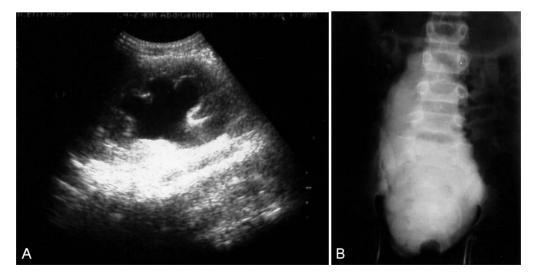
(A) Sonogram shows hydronephrosis. (B) Voiding cystourethrogram shows christmas tree appearance of the dysconfigurated bladder.
